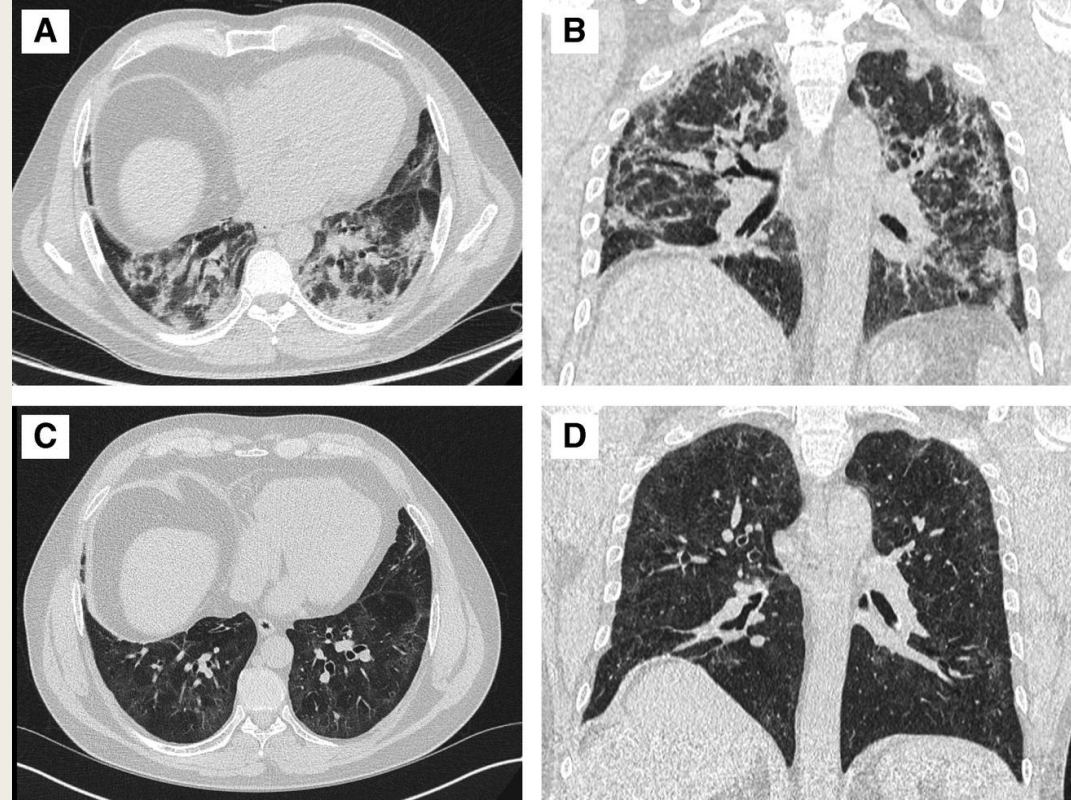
Axial image and coronal reconstruction from computed tomographic (CT) imaging of the thorax acquired immediately before discharge in a previously fit and well 57-year-old man (A and B) shows a radiological pattern of organizing pneumonia disease with predominant peribronchial and perilobular dense consolidation mild traction bronchiectasis of the airways. At this stage, the patient could only walk 30 yards. Follow-up CT imaging of the thorax acquired after 3 weeks of oral prednisolone (C and D) shows resolution of consolidation with residual ground glass and fine subpleural reticulation. The airways still have a slightly nontapering appearance. The patient was now able to run for 30 minutes a day.
